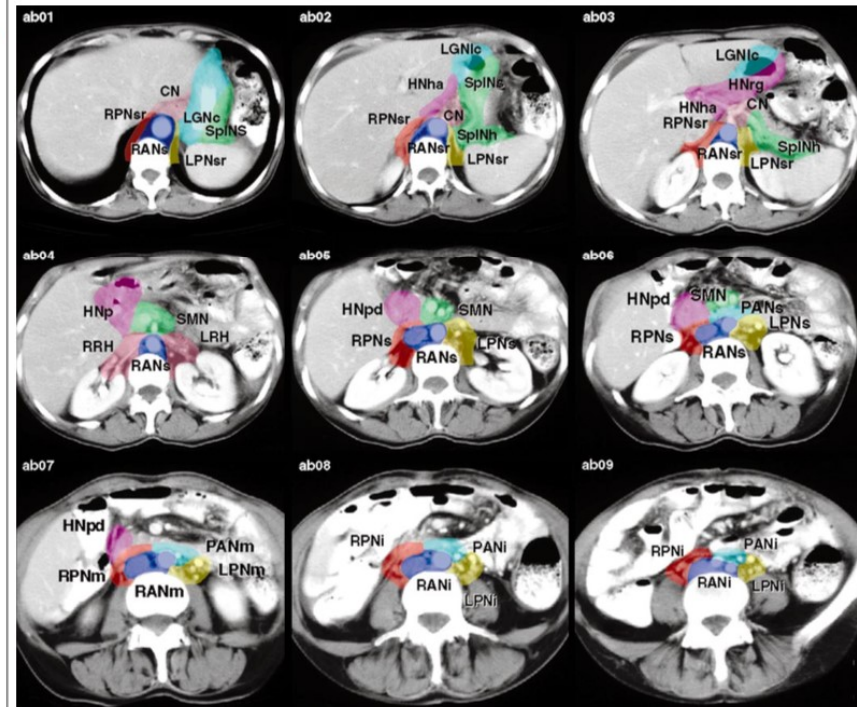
CT images depict the nodal stations in the abdomen (ab).
